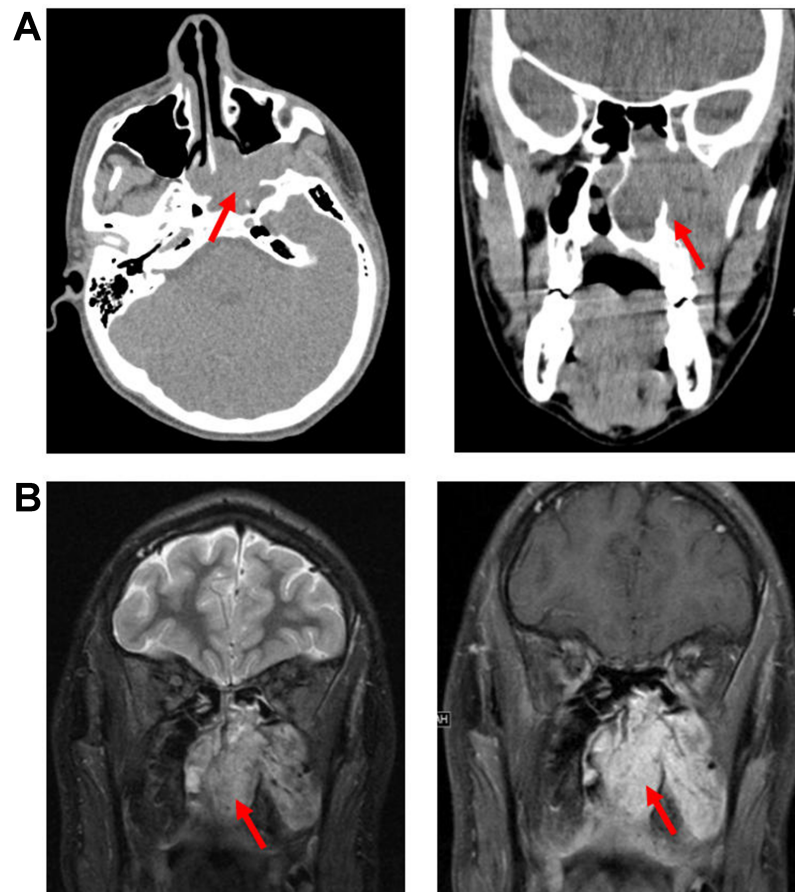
JNA. (A) Axial (left) and coronal (right) non-contrast CT images, and (B) coronal T2-weighted (left) and post-contrast T1-weighted (right) MRI images, demonstrate an expansile, hyperenhancing mass arising from the left PPF and extending into the left nasal cavity (arrows). JNA: Juvenile nasopharyngeal angiofibroma; CT: computed tomography; MRI: magnetic resonance imaging; PPF: pterygopalatine fossa.
